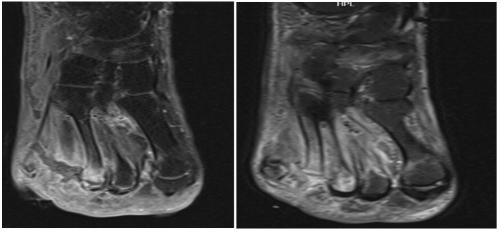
MRI 10 days after surgery (small fluid collections).
